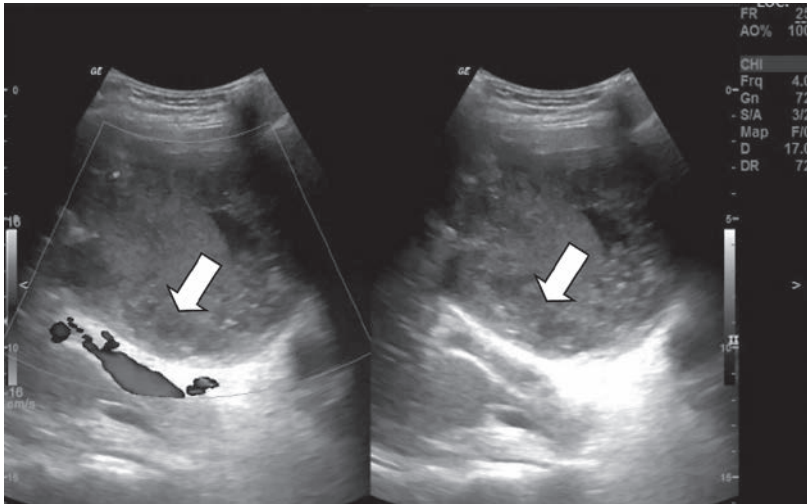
Ultrasound hepatobiliary-hypoechoic lesion at segment V (arrows). Presence of echogenic and internal debris within with minimal peri splenic free fluid.
